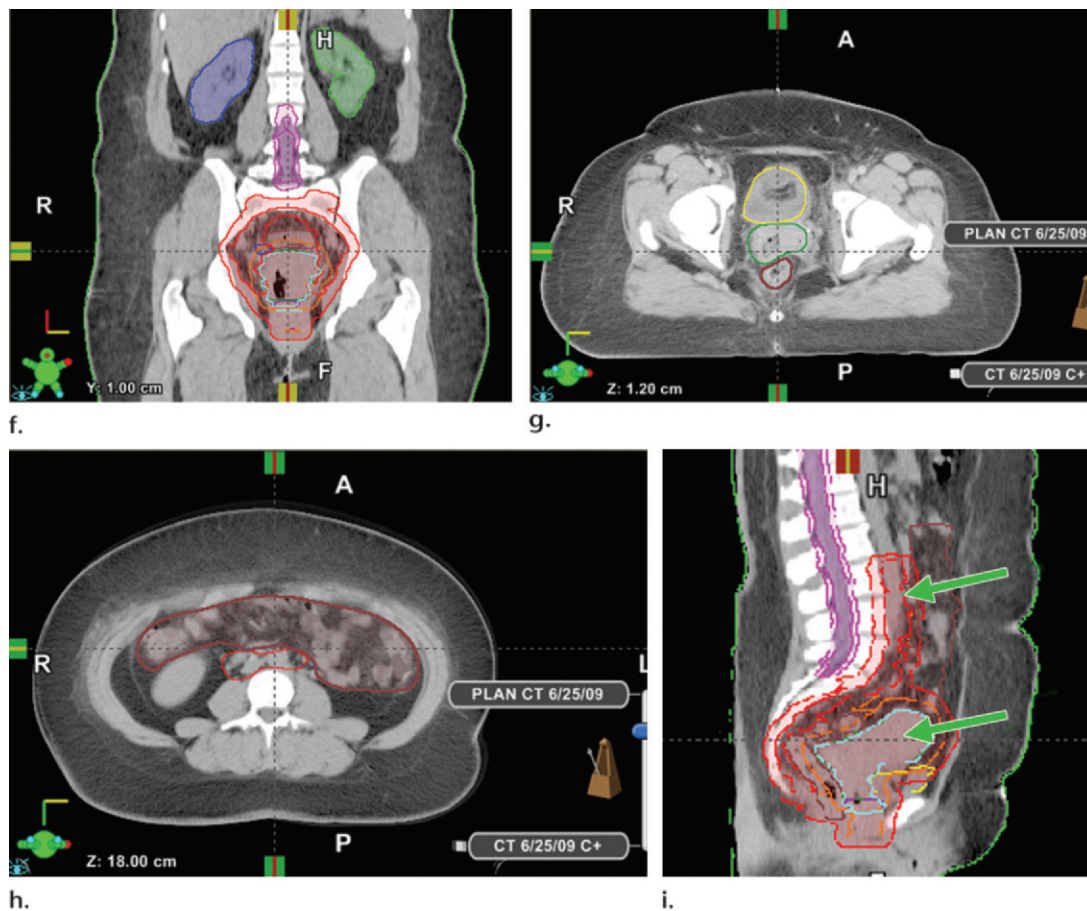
(continued). (f–i) Coronal (f), axial (g, h), and sagittal (i) CT images show contouring of pertinent normal structures. Typical radiation dose requirements for the target structures and dose limits for the normal structures are 85 Gy or more for the tumor and uterus (aqua contour on f, lower arrow on i), 45–66 Gy for the lymph nodes (red contour, upper arrow on i), maximum dose of 25 Gy or less for each kidney (left kidney, green contour on f; right kidney, dark blue contour on f), maximum dose of 45 Gy or less for the spinal cord and cauda (hot pink contour on f, i), 45 Gy or less for the bladder (yellow contour on g, i), less than 40 Gy for the rectum (reddish brown contour on g), and 50 Gy or less for the bowel (reddish brown contour on h).
